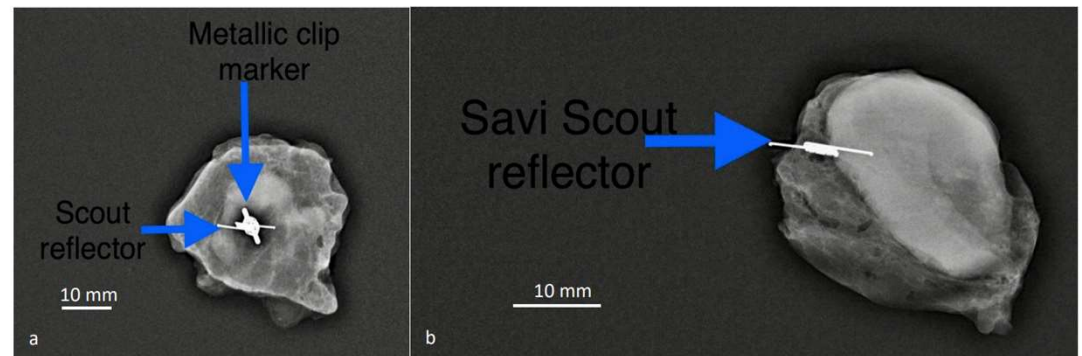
In (a), the patient had a metallic marker clip deployed within the pathological lymph node at the time of biopsy before neoadjuvant chemotherapy (NACT) and a second localization procedure using Savi Scout prior to surgery. In (right), the patient had the Savi Scout reflector at the time of biopsy prior to NACT thus avoiding a second procedure. There were no MRI artifacts related to the Savi Scout reflector in (b). The surgical procedure of identification and retrieval of the Savi Scout reflector took 15 min. Scale bar: 10 mm.
